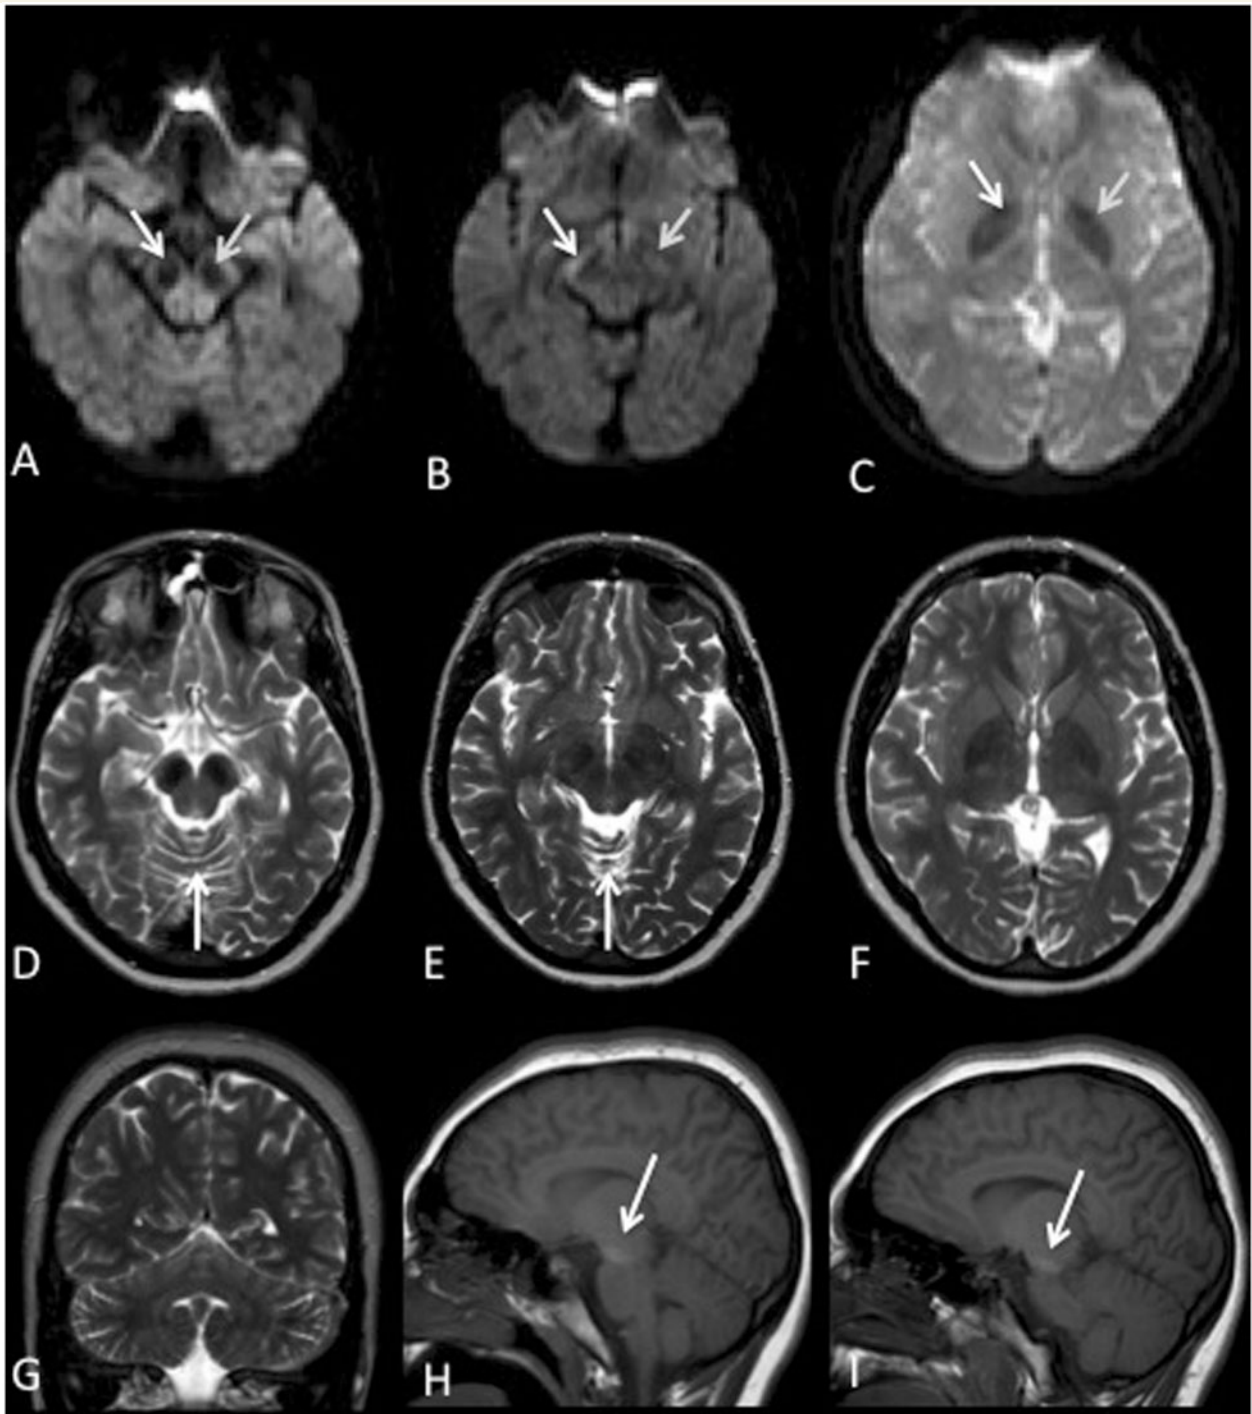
Early MRI features of BPAN. (A–C) Axial diffusion-weighted images acquired with an echo planar sequence through the midbrain, cerebral peduncles and basal ganglia shows marked hypointensity resulting from the iron deposition in (A and B) substantia nigra and (C) globus pallidi (arrows). (D–F) Corresponding T₂-weighted slices reveals hypointense signal in the corresponding regions as well as vermian atrophy (arrow). (G) Coronal T₂-weighted demonstrates more global cerebellar atrophy. (H and I) Sagittal images (*right* and *left*) show hyperintensity of the substantia nigra on T₁-weighted imaging within the midbrain and cerebral peduncles (arrows).
